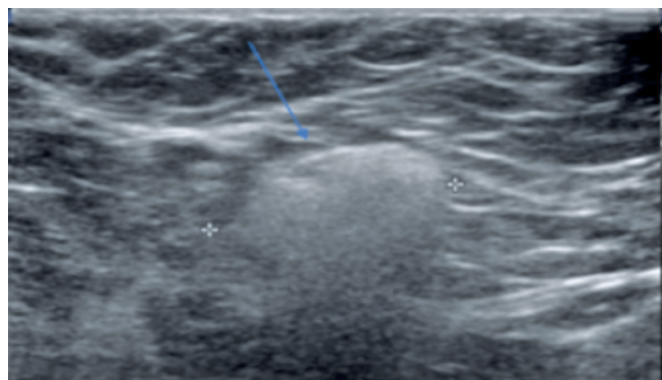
Ultrasonography of the right axilla showing the classic “snowstorm sign,” which represents the presence of free silicone droplets mixed with normal nodal tissue, resulting in a characteristic heterogeneous echogenic appearance with dispersion of the ultrasound beam. This is considered one of the most reliable radiological signs of extracapsular breast implant rupture
